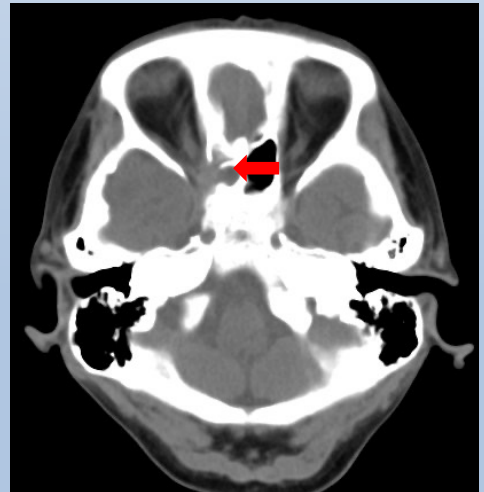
and 1b showing CT brain image and MRI brain image of right sphenoidal sinus mass extending into right orbit. 12
